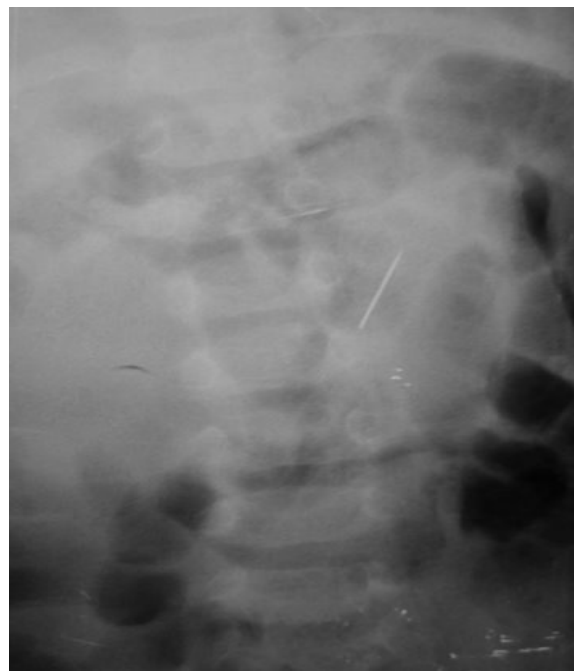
Anteroposterior plain radiograph of the thoracolumbar spine showed a metallic foreign object.
